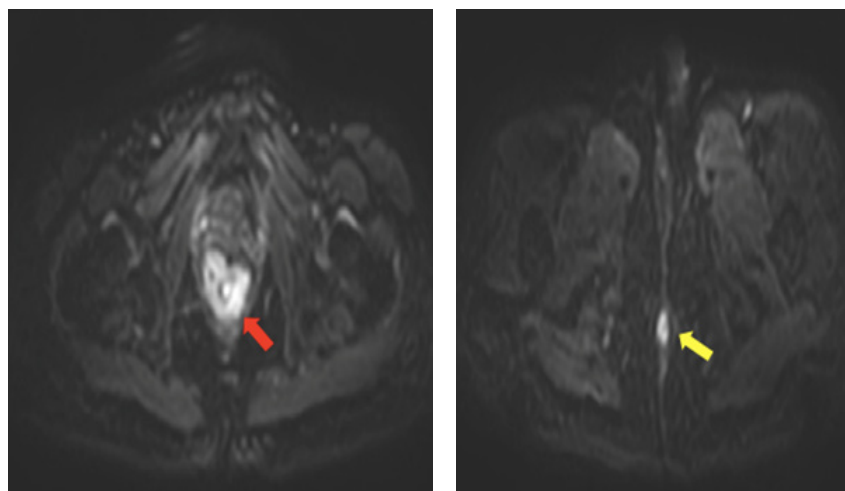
Abdominopelvic MRI with diffusion-weighted sequence, axial sections, showing the rectal (red arrow), and anal (yellow arrow) masses with hyperintense diffusion signal.
